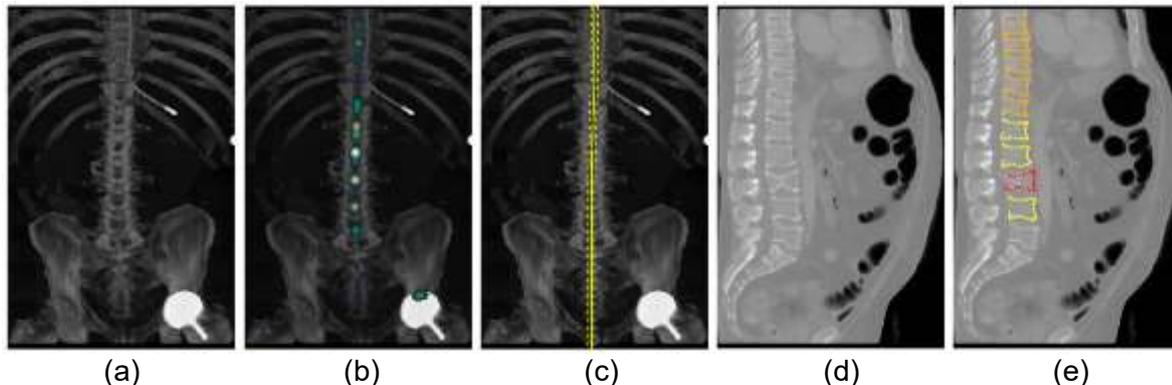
Processing 3D CT image volumes in a series of 2D steps. The original volume is summed in the anteroposterior direction (a) and an initialisation model finds the spinal mid-line (b, c). A lateral image is produced from a thick slice around the mid-line (d), then vertebrae are identified by an RFRV-CLM (e) and classified as normal (yellow) or fractured (orange=mild, red=severe) based on height reduction.
